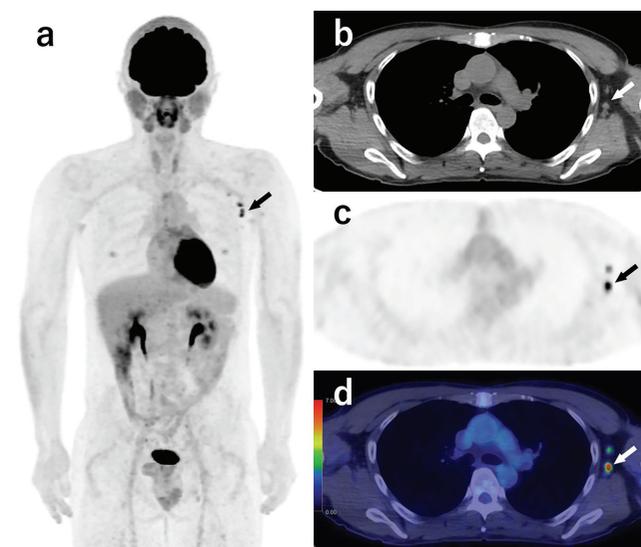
(a) MIP, (b) CT, (c) PET, and (d) fused PET/CT. ^{18}F -FDG PET/CT images of the representative case of a 39-year-old male in which ^{18}F -FDG uptake was observed in the axillary LN on the ipsilateral side to the influenza vaccination arm (arrows). The interval time from vaccination to PET/CT exam was 3 days. The SUV_{max} was 7.7. The size of the largest hypermetabolic LN was 5.2 mm in short-axis diameter. MIP: Maximum intensity projection, PET: Positron emission tomography, CT: Computed tomography, FDG: Fluorodeoxyglucose, LN: Lymph node, COVID-19: Coronavirus disease-2019, SUV_{max} : Maximum standardized uptake value
